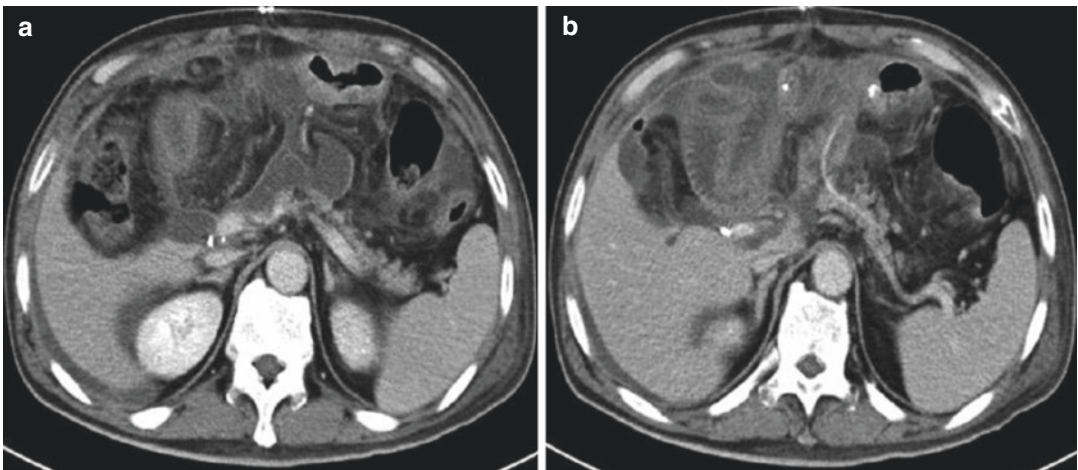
(a, b) CT image showed pancreatic fistula after PD procedure
